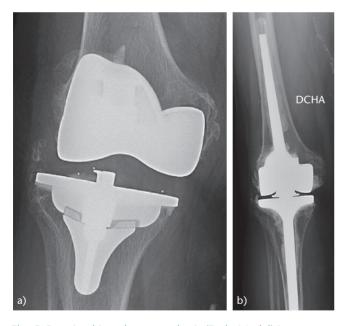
Rotating hinge knee prosthesis (Endo-Model) in a revision TKA due to severe instability and ligamentous insufficiency of the primary TKA in an 82-year-old woman. (a) Pre-operative anteroposterior (AP) radiograph showing subluxation of the primary TKA; (b) AP radiograph 5 years after the procedure. The result was good.
